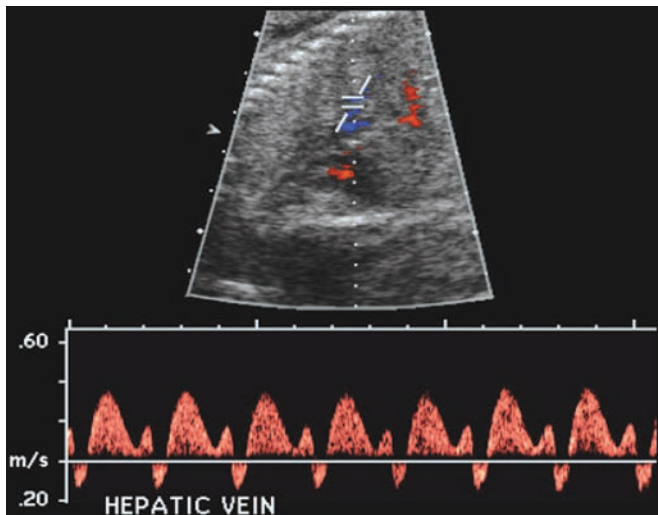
Doppler flow waveforms in the HV: a physiological slight reversal flow is recorded during atrial contraction (a).
